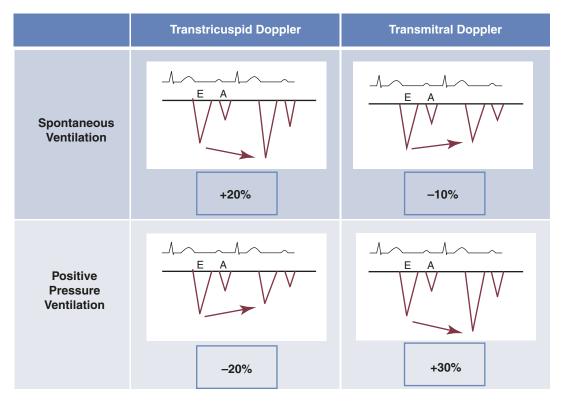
Spectral Doppler patterns of the transtricuspid and transmitral inflow demonstrate normal respirophasic variation during inspiration for both spontaneous ventilation and positive pressure ventilation
